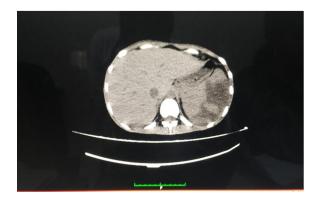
CT abdomen splenic infarct
